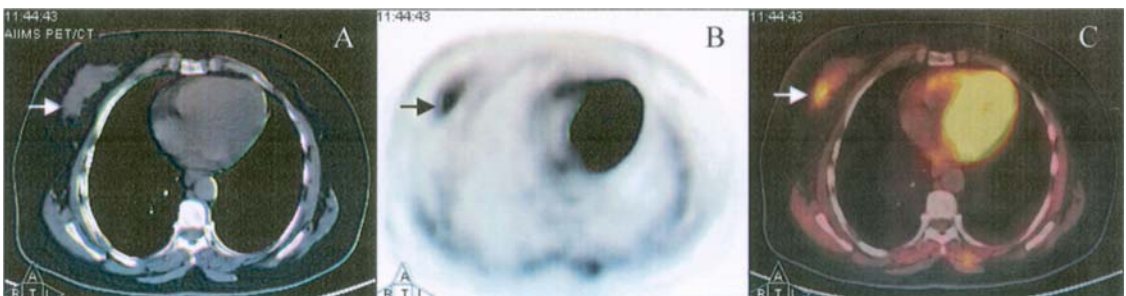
A 54-year old female with known right breast cancer, underwent whole body PET-CT scan for staging. NCCT chest demonstrates dense right breast (A). PET scan shows increased FDG uptake (SUV 1.7) in the entire right breast with a focal area of relatively increased uptake (SUV 2.7) (B). PET-CT confirmed increased FDG uptake in dense breast with a focal area of increased uptake in outer quadrant of right breast (C). In this patient increased FDG uptake in dense breast can mask lesion visually. However, SUV was above the cut off threshold of 2.5
